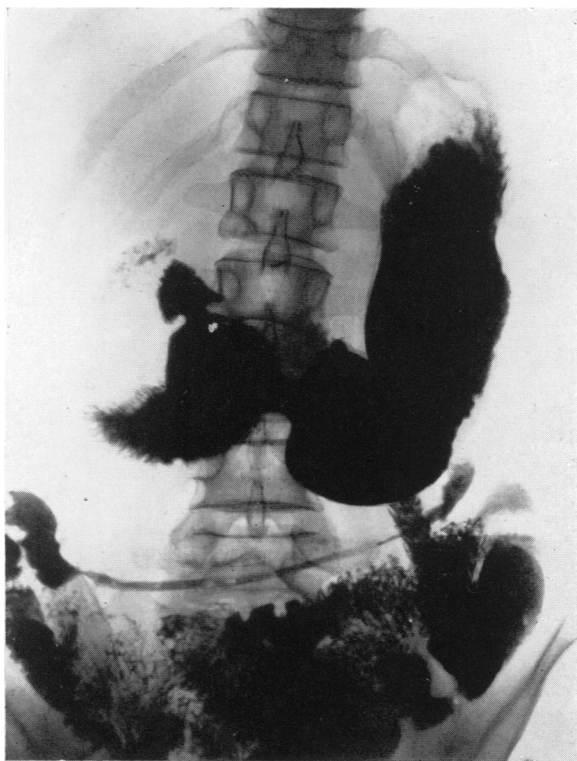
X-ray taken within 15 minutes of ingestion of barium, showing the rapid transit and barium already in the colon.
